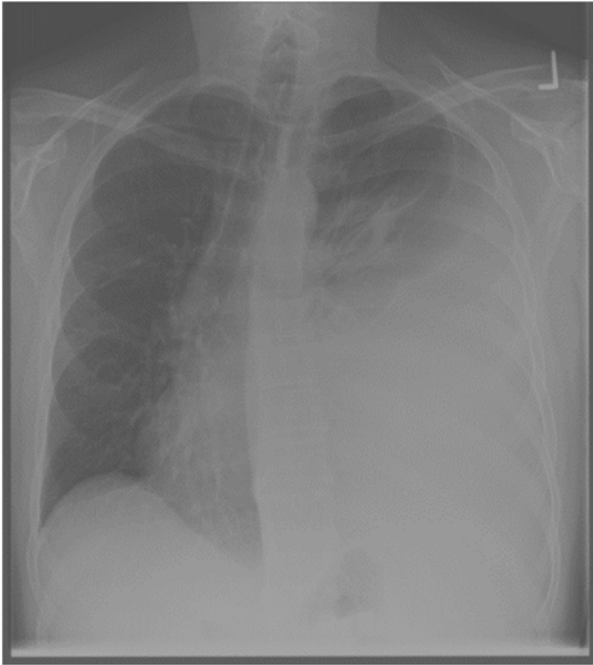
X-ray of the chest – AP view.
